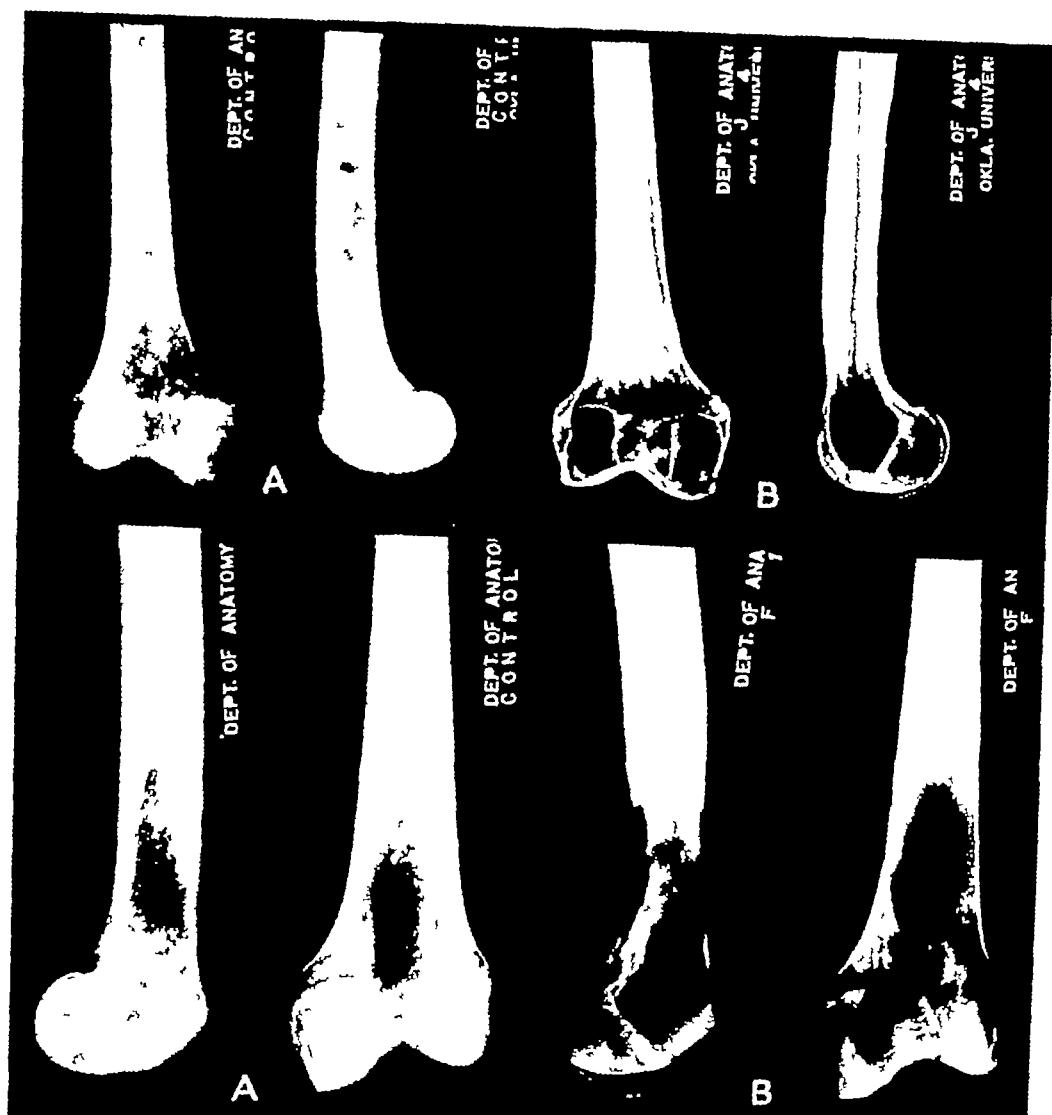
A (upper) Roentgenogram of the distal end of a normal macerated femur
